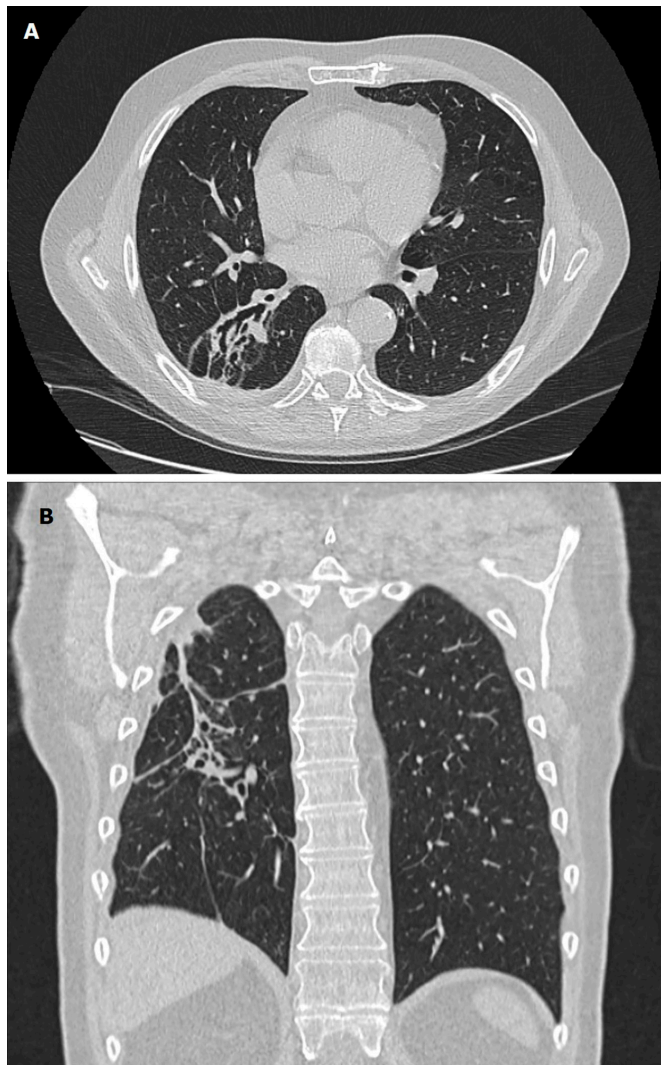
Follow-up non-contrast chest-CT performed 1 year after initial CT scan, showing a complete resolution of the residual cavity, with residual fibrosis with traction bronchiectasis–bronchiolectasis located in the posterior segments of the upper and lower lobes. (A) Axial and (B) coronal views.
